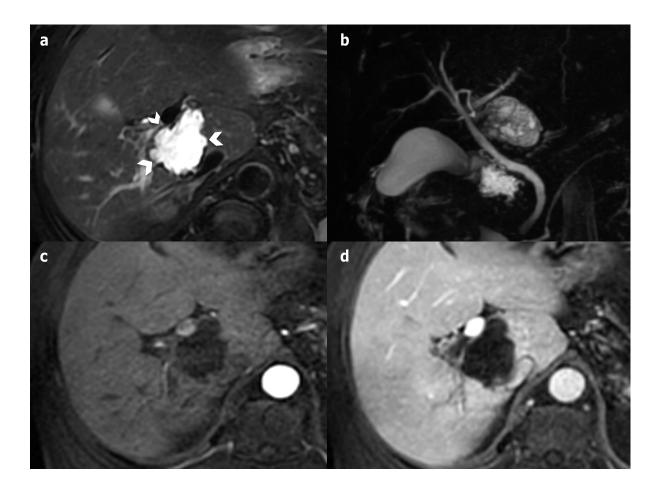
Cyst echinococcosis 1 in a 50-year-old female patient. (a) Axial T2-weighted magnetic resonance imaging shows a highly hyperintense lesion with lobulated margins that are typically hypointense. (b) Coronal 3D magnetic resonance cholangiopancreatography allows eliminating a biliary fistula. (c and d) Axial T1 fat-sat-weighted without and with contrast at portal-venous phase does not show any enhancement.
